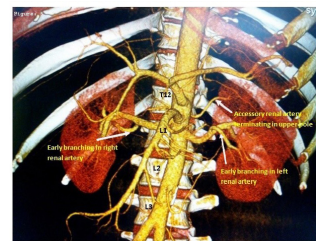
CT angiographic image showing left accessory renal artery to upper pole of kidney (SPA)
